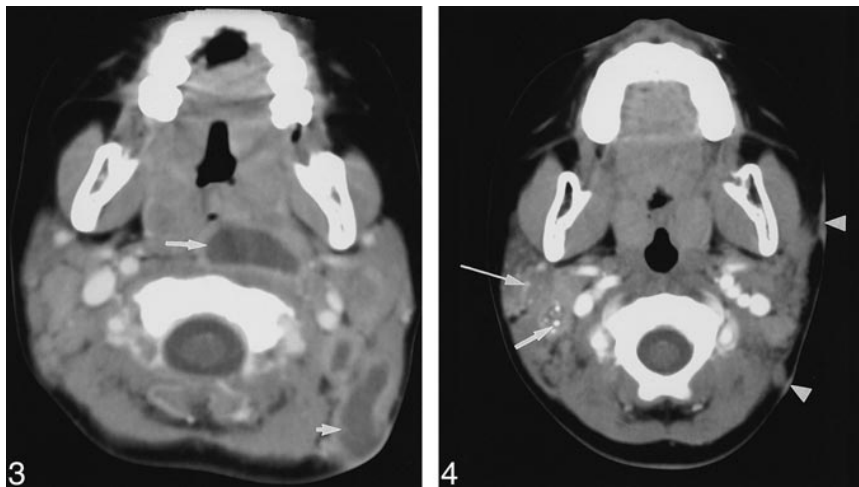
Case 8: Girl, two years six months old, with 4-week history of enlarging left posterior triangle neck mass and deviation of oropharynx to right. Axial contrast-enhanced CT scan shows low-density ring-enhancing spinal accessory adenopathy (short arrow) with extension to skin. Enlarged low-density ring-enhancing left retropharyngeal adenopathy (long arrow) causing distortion and narrowing of oropharynx is present.
